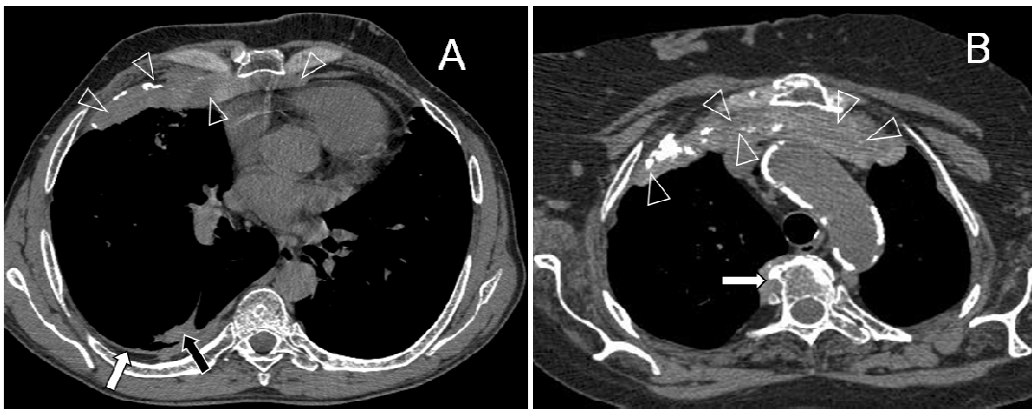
Pleural masses. A. HRCT scan of the lung of a 55-year-old former pipefitter with RPF. There is a large anterior pleural mass (maximum dimensions of 30 mm x 150 mm) that continues into the mediastinum (arrowheads) and a thinner dorsal diffuse pleural thickening (white arrow) with a rounded atelectasis (black arrow). The patient had undergone left-sided pleural decortication 10 years earlier.
